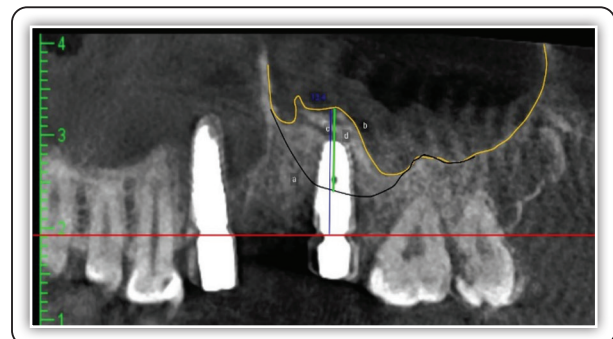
Sinus radiograph showing difference between pre and postoperative bone height and sinus augmentation (letter (a) preoperative sinus floor, letter (b) postoperative sinus floor, letter (c) bone height, letter (d) vertical bone gain.
